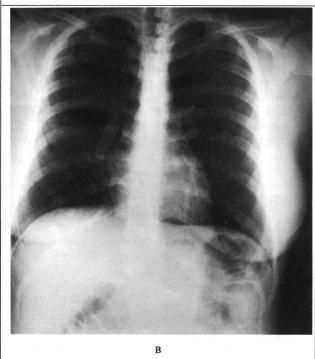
Examples of face (A) and normal chest X-ray film (B) stimuli.
